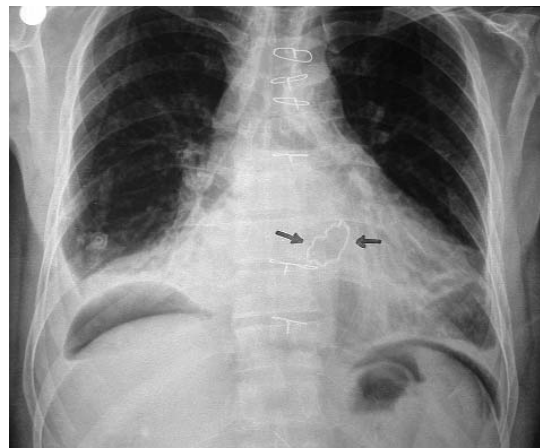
Postoperative chest X-ray showed optimal configuration of the ring
